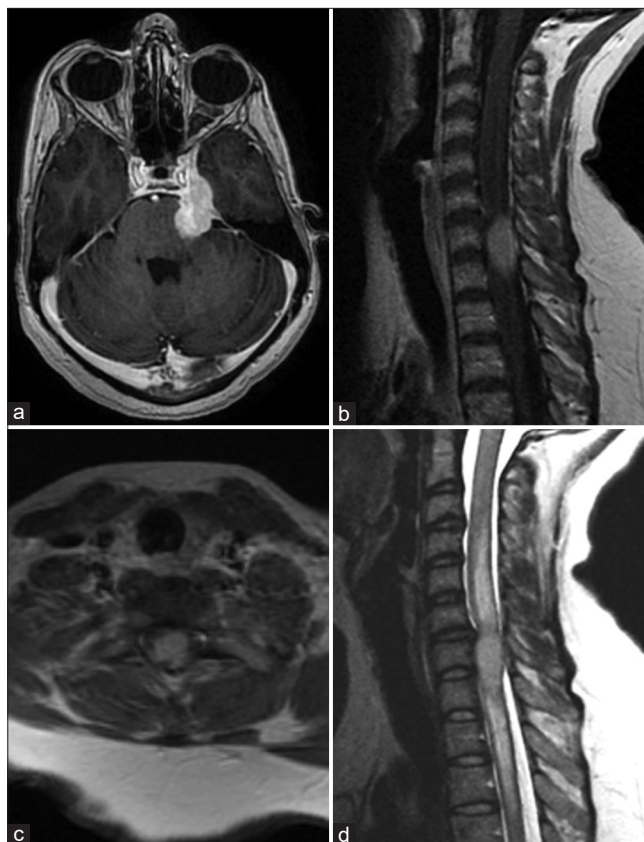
Magnetic resonance imaging of the trigeminal nerve and spinal intramedullary malignant peripheral nerve sheath tumors. Axial T1 with gadolinium cranial imaging demonstrating the left trigeminal nerve mass (a). Sagittal (b) and axial (c) T1 with gadolinium spinal imaging demonstrating the intramedullary mass. Sagittal T2-weighted imaging showing the same intramedullary mass with surrounding cord edema extending caudally and rostrally (d).
